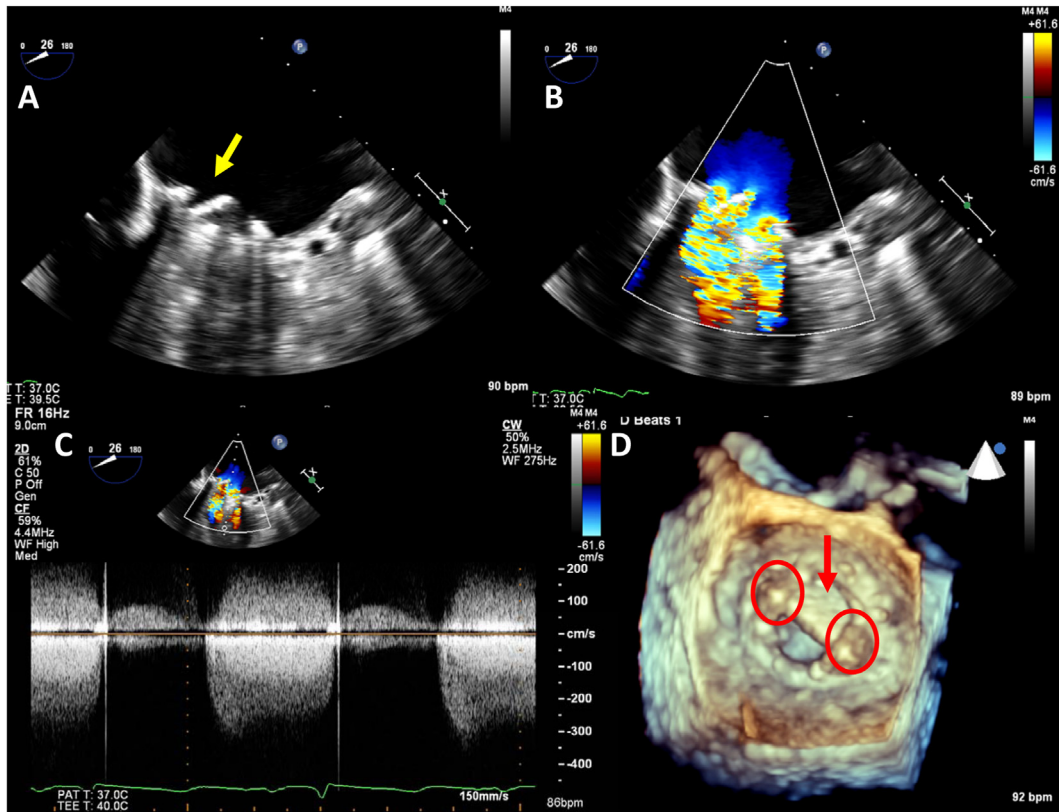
A case of severe mechanical mitral valve stenosis secondary to thrombus formation. (A) Two-dimensional TEE, midesophageal view in diastole, shows restricted disk motion (*yellow arrow*) with high inflow color aliasing (B) and severe prosthetic stenosis (mean gradient, 29 mm Hg at a heart rate of 86 beats/min) on CW Doppler (C). (D) Real-time 3D TEE of the mechanical mitral valve (en face view) showing restricted disk motion in diastole (*red arrow*) and two immobile masses (*circles*) along the hinge points of the mechanical valve.
